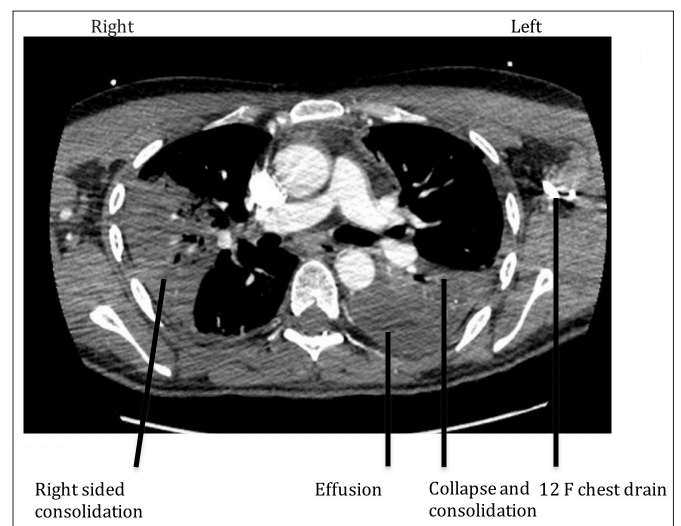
Chest CT scan post drain insertion, which shows left effusion, collapse and consolidation and right sided consolidation
